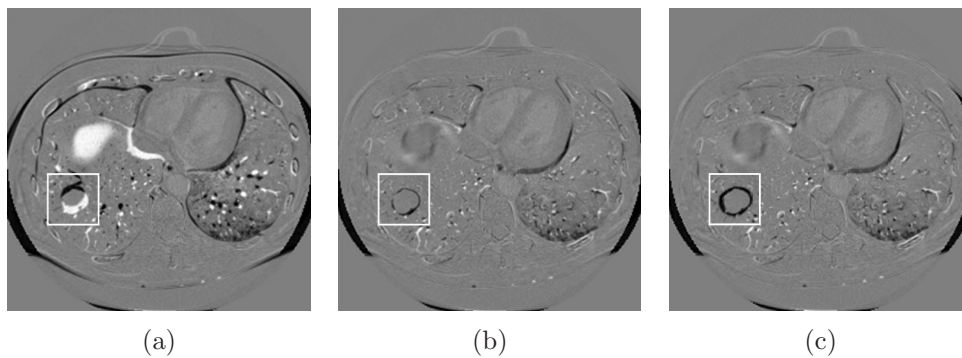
BS registration compared with BSF for the CT thorax follow-up data. Difference images of the registration result with the fixed  $t_0$  image are shown. (a) for affine, (b) for BS, and (c) for BSF registration. The white box shows a tumour location.
